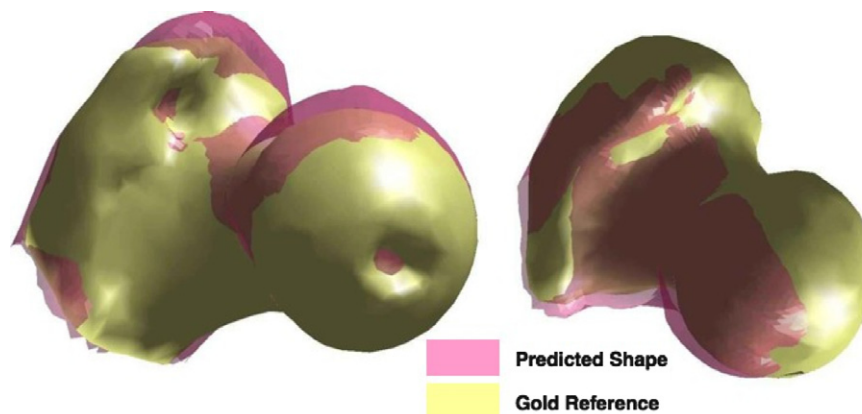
Ultrasound-based prediction: Predicted models overlaid onto “gold” references. Bone 1 (left): 3.08 mm mean error and Bone 2 (right): 2.94 mm mean error.
